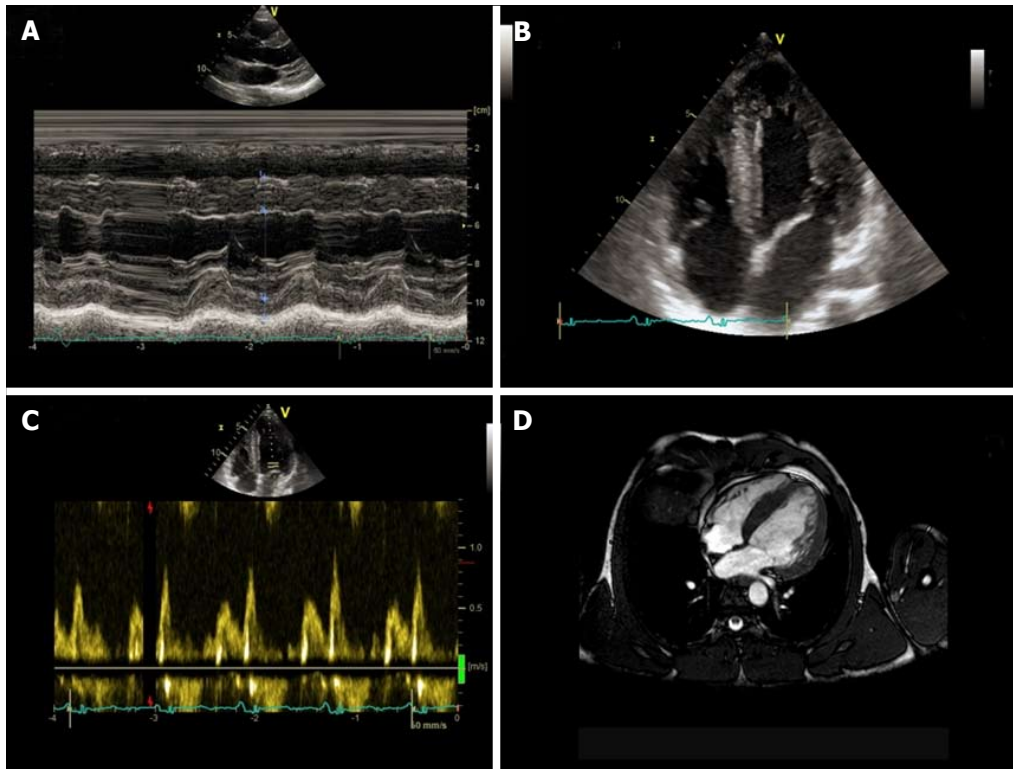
Non-invasive evaluation of power athlete abusing of steroids. Standard M-mode (A) and 4-chamber view B-mode (B) echocardiography, evidencing severe left ventricular hypertrophy, with diastolic dysfunction (C) underlined by Doppler transmitral flow pattern. Cardiac magnetic resonance confirmed severe left ventricular hypertrophy (D).
